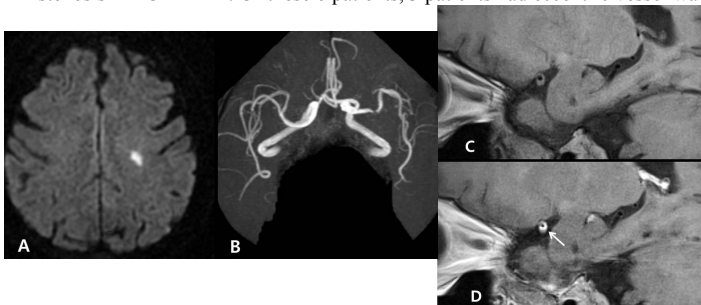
DWI image (A) shows an acute lacunar like infarcted lesion at the left centrum semiovale. TOF-MRA (B) shows significant stenosis at the left MCA MI. Precontrast 3D Black-Blood image (C) reveals diffuse thickened vessel wall. Postcontrast 3D Black-Blood image (D) visualizes diffuse eccentric vessel wall enhancement(arrow).
